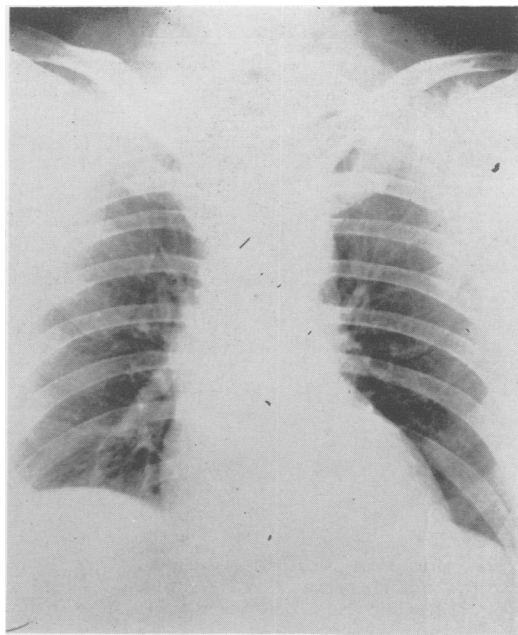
Roentgenogram of chest in Case 5, showing widening of the supracardiac mediastinal shadow.
